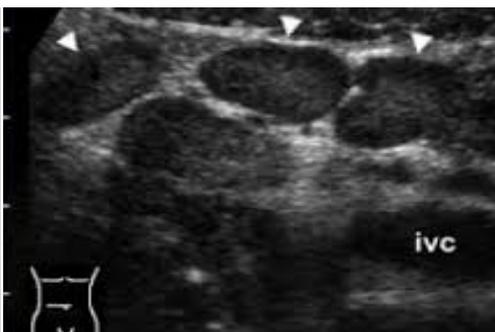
ultrasound of abdomen shows abscesslymphadenopathy Figure 4: ultrasound of abdomen shows multipleAmebic Liver
